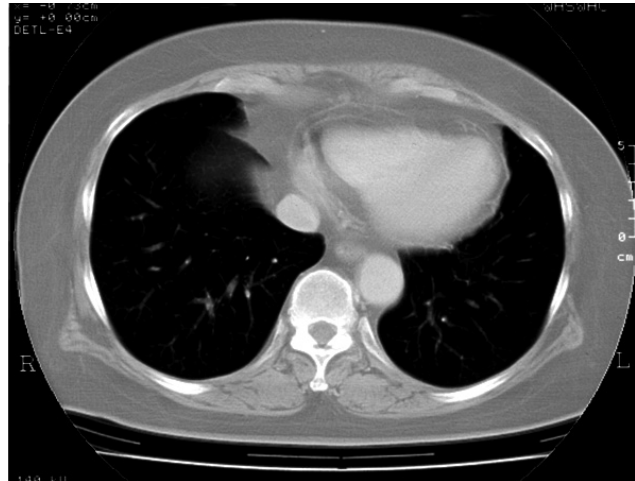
A) Pretreatment CT scan showing 3 cm metastasis of the left lower lobe lung. B) CT scan showing complete disappearance of the left lower lobe lung metastasis. There was no evidence of recurrence nor metastasis after the 6 courses of ifosfamide, doxorubicin and cisplatin.
